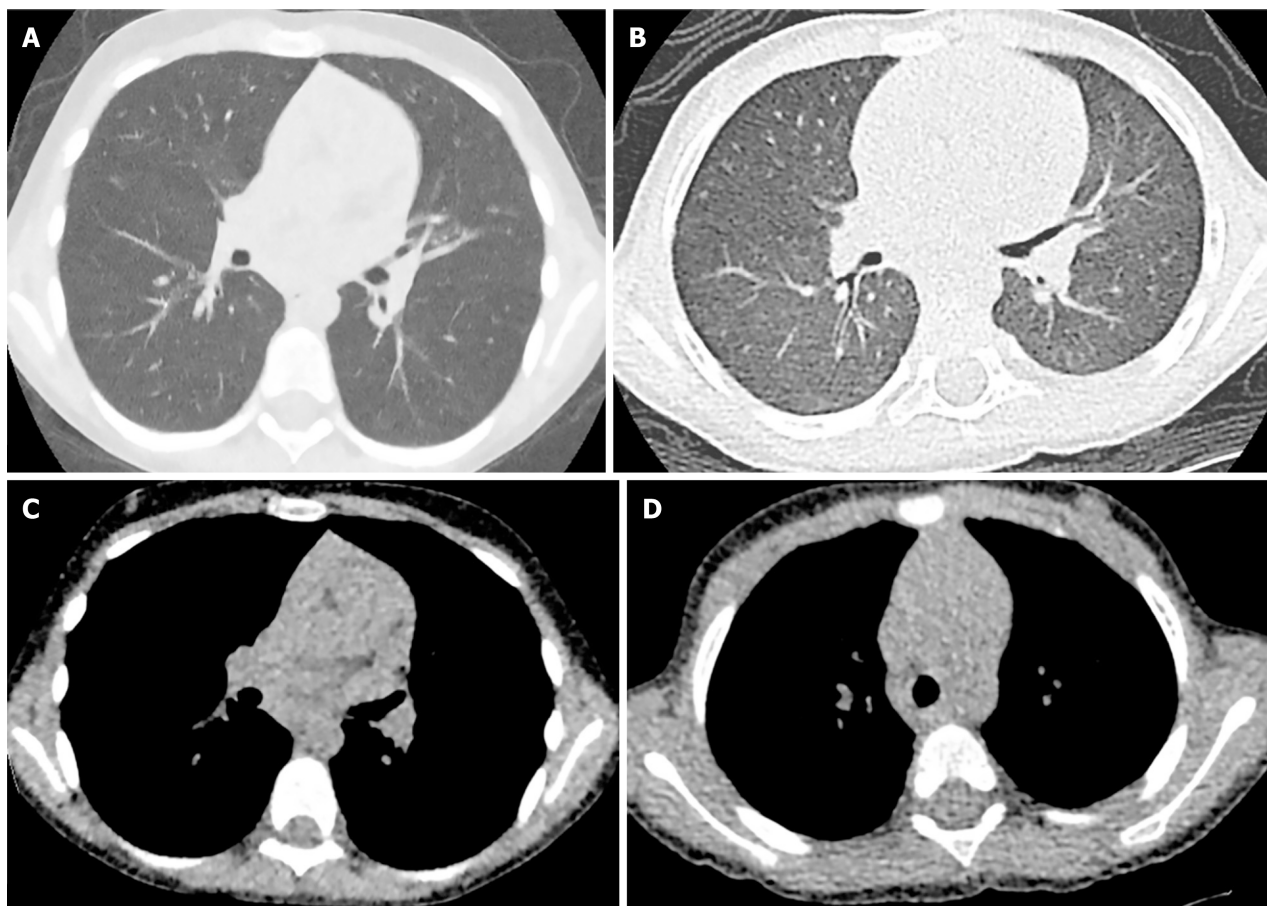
Comparison of ultra-low dose computed tomography chest and modified low dose computed tomography chest protocols. A-D: Comparison of axial ultra-low dose chest computed tomography (CT) in lung windows (A) and soft tissue windows (C) and modified low dose chest CT images in lung windows (B) and soft tissue windows (D) in the same paediatric patient acquired 7 years apart. These images demonstrate the acceptable assessment of lung structure in ULDCT chest imaging.
